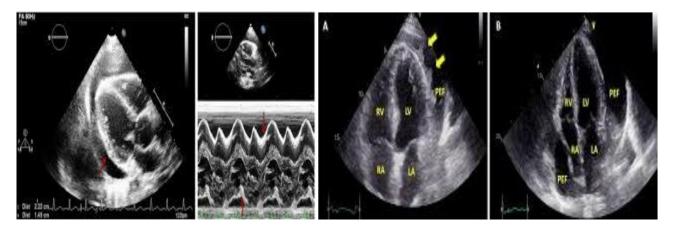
Figure III and Figure IV: Transthoracic Echocardiography Showing Severe Pericardial Effusion (40 Mm Along Posterior Wall) with Diastolic Collapse of Right Atrium and Right Ventricles
